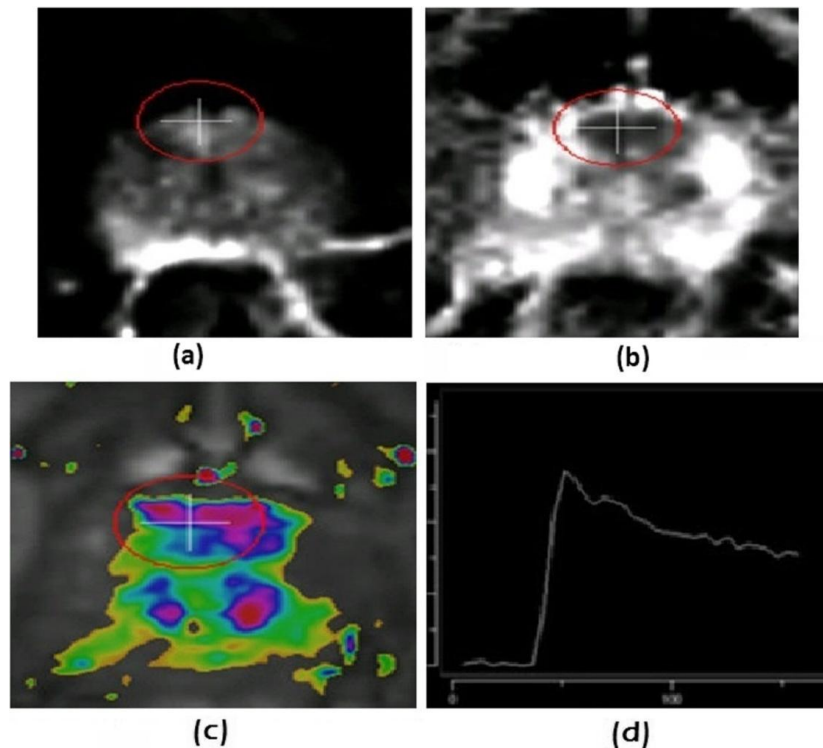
58yrs old patient, with felt P/R hard suspicious prostate nodule, (a and b) DWI and ADC map revealed nodular lesion at the anterior aspect of PZ with significant diffusion restriction, ADC value measuring “0.8763”, (c and d) DCE-MRI revealed moderate enhancement with type III enhancement curve (PI-RADS 2.0, score = 4. All MP-MRI findings are collectively diagnostic of Malignant lesion. Histo-pathology: Adeno-Ca. (Gleason score 8).
